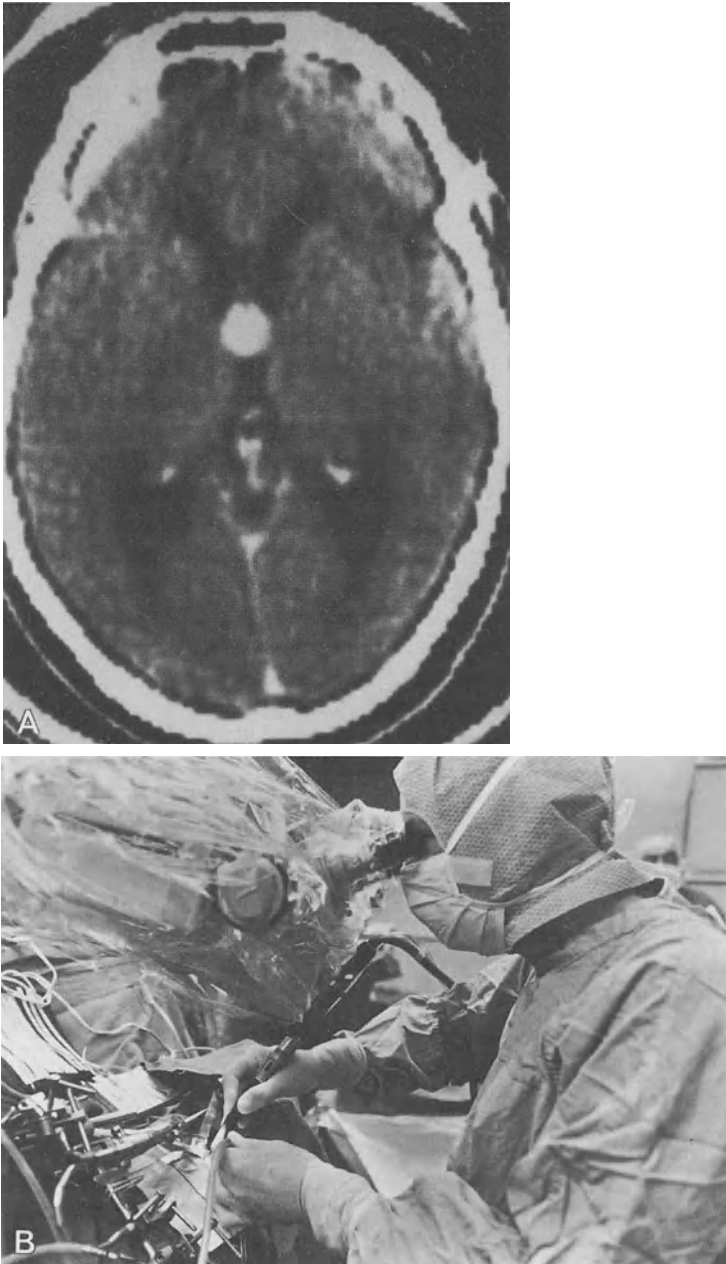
A CT scan showing large meningioma of the pineal region. The Cavitron was used to remove this tumor. B Posterior fossa exposure used in the removal of this meningioma
